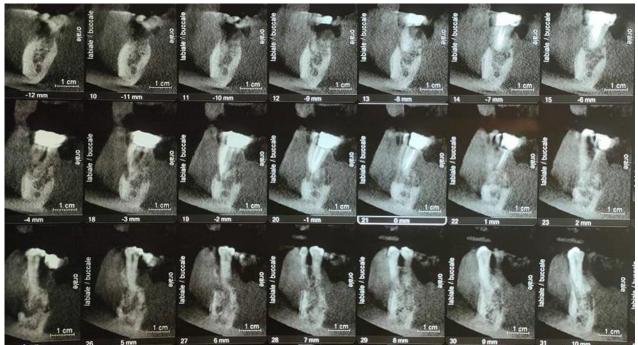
CBCT scan showing oblique-coronal sections: lytic bone destruction extending beyond the region of alveolar bone and lingual area of the right hemi-mandible
